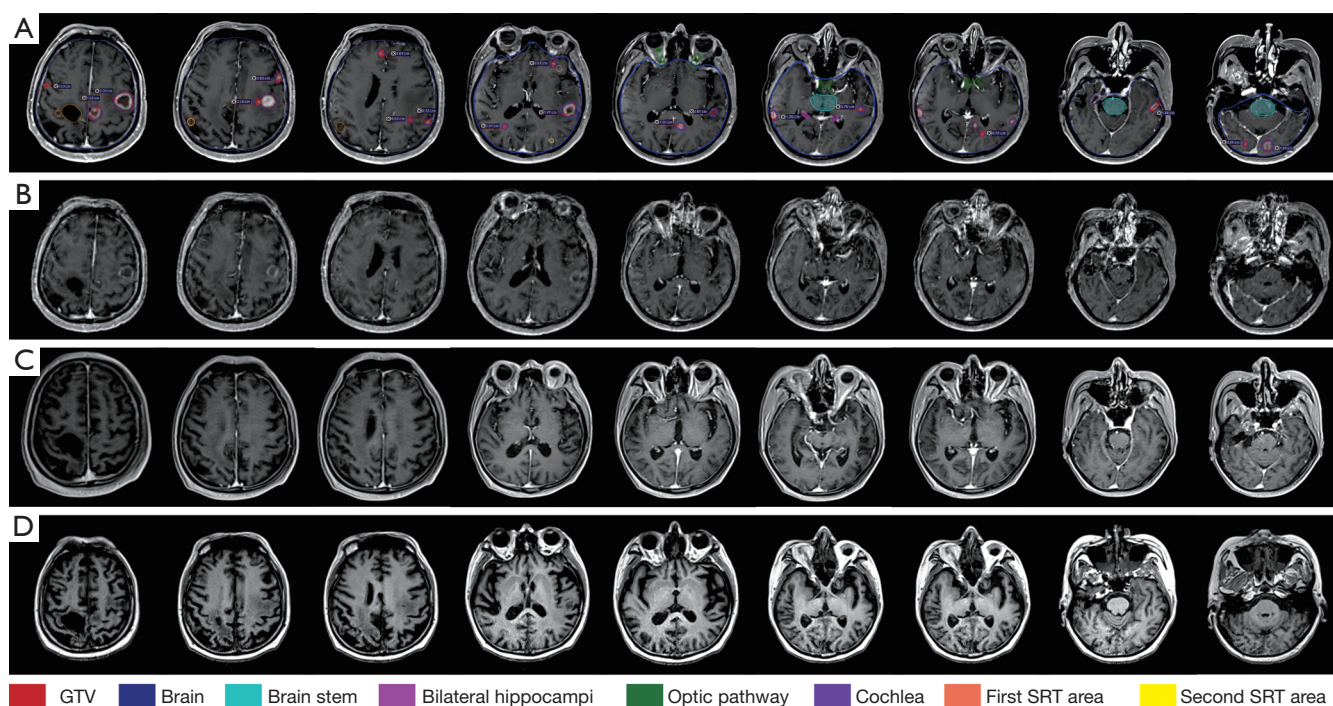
Changes in the 19 intracranial lesions after the second recurrence of distant brain failure. (A) The location of GTV and OARs for the second reirradiation of the HT-HSRT from positioning MRI performed on September 7, 2023. (B) Intracranial lesion distribution on contrast-enhanced MRI performed on October 3, 2023, after the third SRT. (C) The intracranial lesion distribution on the non-contrast-enhanced MRI in other institution performed on February 2, 2024. (D) The intracranial lesion distribution on contrast-enhanced MRI performed on May 31, 2024. GTV, gross tumor volume; SRT, stereotactic radiotherapy; OARs, organs at risk; HT-HSRT, helical tomotherapy-based hypofractionated stereotactic radiotherapy; MRI, magnetic resonance imaging.
